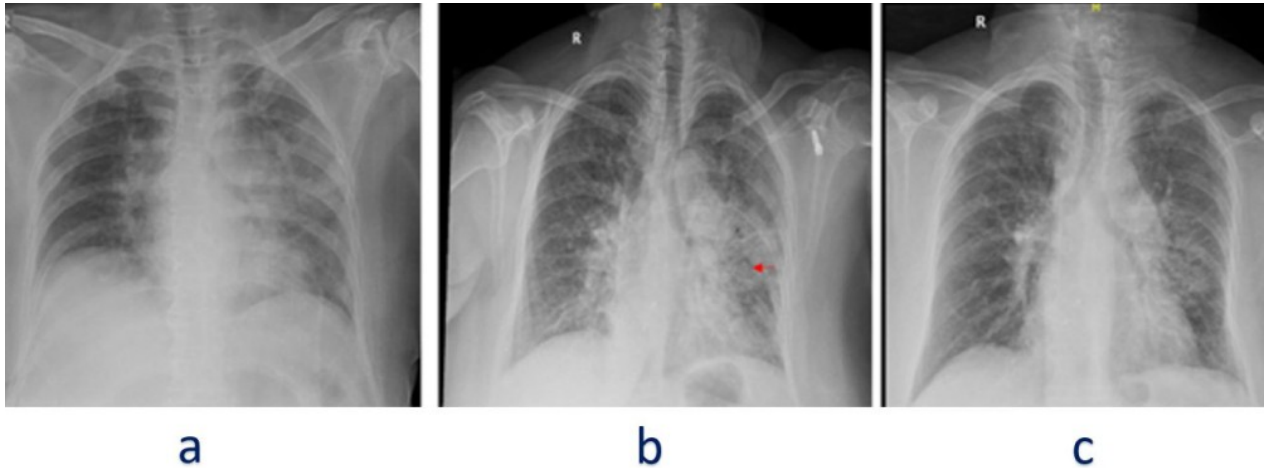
a) Initial x ray chest PA on presentation. b) X-Ray taken after 3 days of antibiotic therapy when the patient showed clinical deterioration. Red arrow showed a halo sign within a dense consolidation in the radiation field. Non homogenous opacities can be seen in the left lower zone and right mid zone. c) Showed partial clearance of shadows on the 4th day of steroid therapy.
